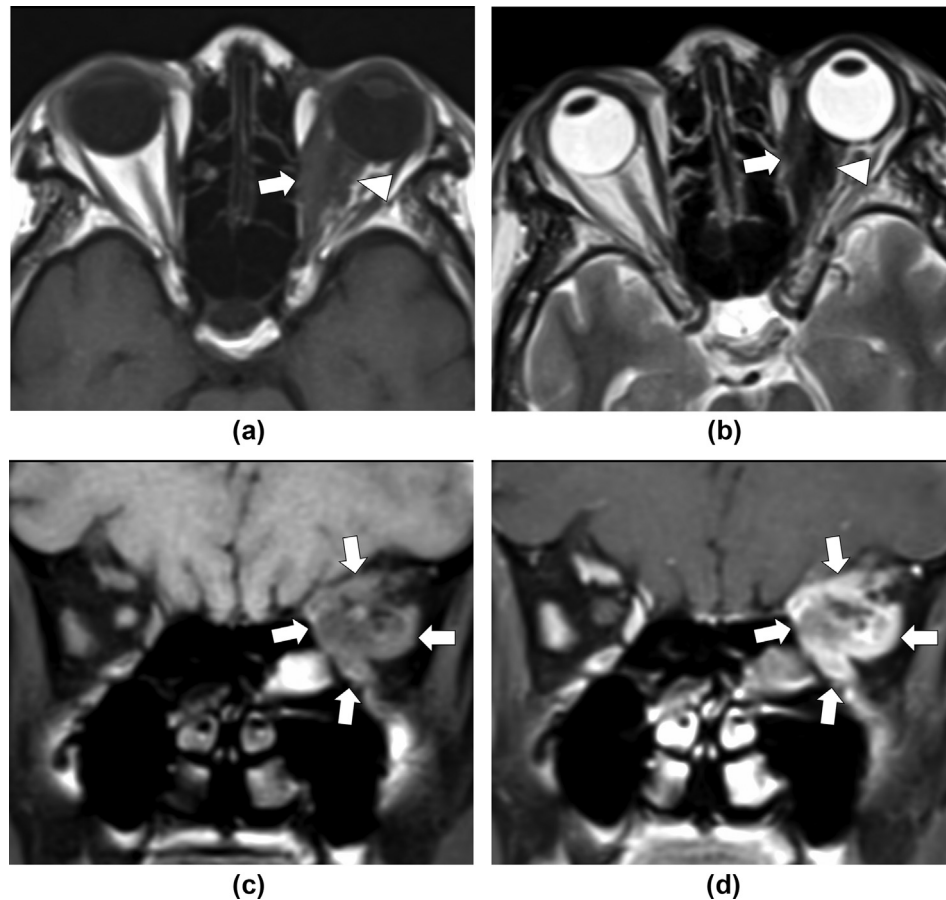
EOM metastases case 15 presents as multiple infiltrative tumours. A 63-year-old woman presented with diplopia and reduced visual acuity as a 10-year recurrence of gastric cancer. (a) Axial T1-weighted image shows an infiltrative mass in the left medial rectus muscle (arrow) and adjacent fat tissue (arrowhead). (b) On the T2-weighted image, the mass shows a mixture of intermediate and low intensities (arrow and arrowhead). (c,d) Coronal pre- and contrast-enhanced fat-suppressed T1-weighted images show multi-muscular involvement with heterogeneous enhancement (arrows).
